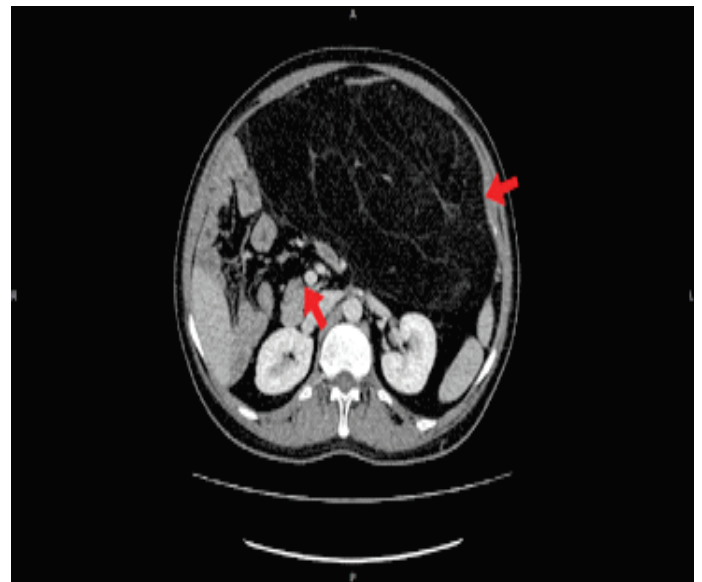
CT with Contract
